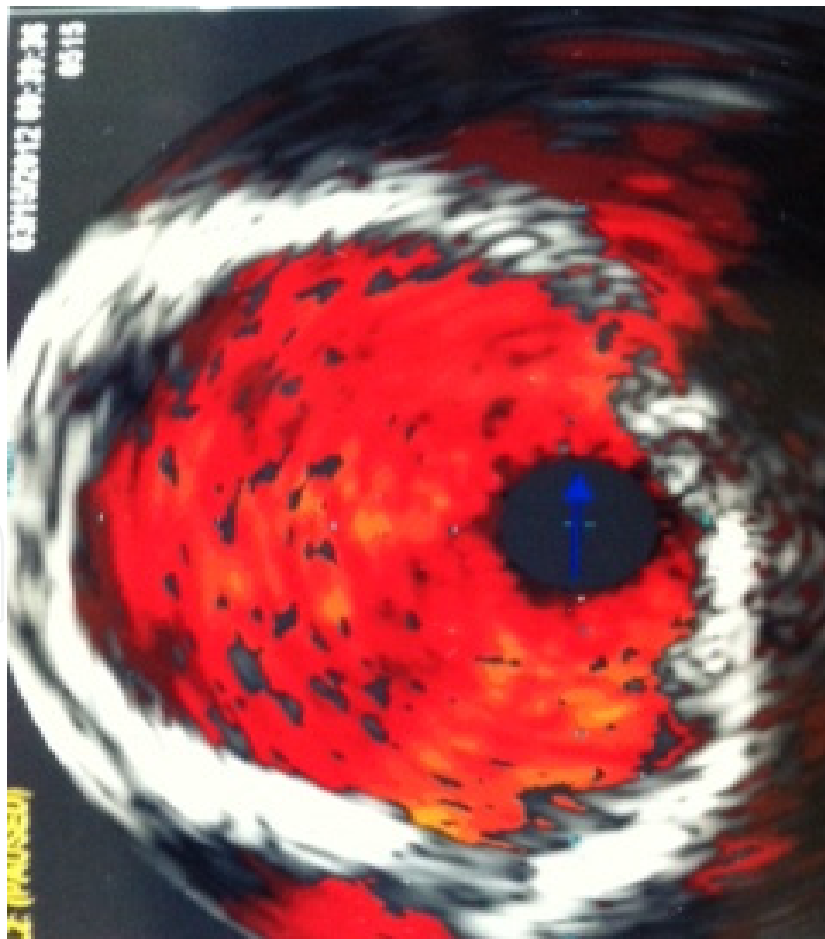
Intravascular ultrasound showing pseudoaneurysm at the 20'clock position with disrupted endothelium
